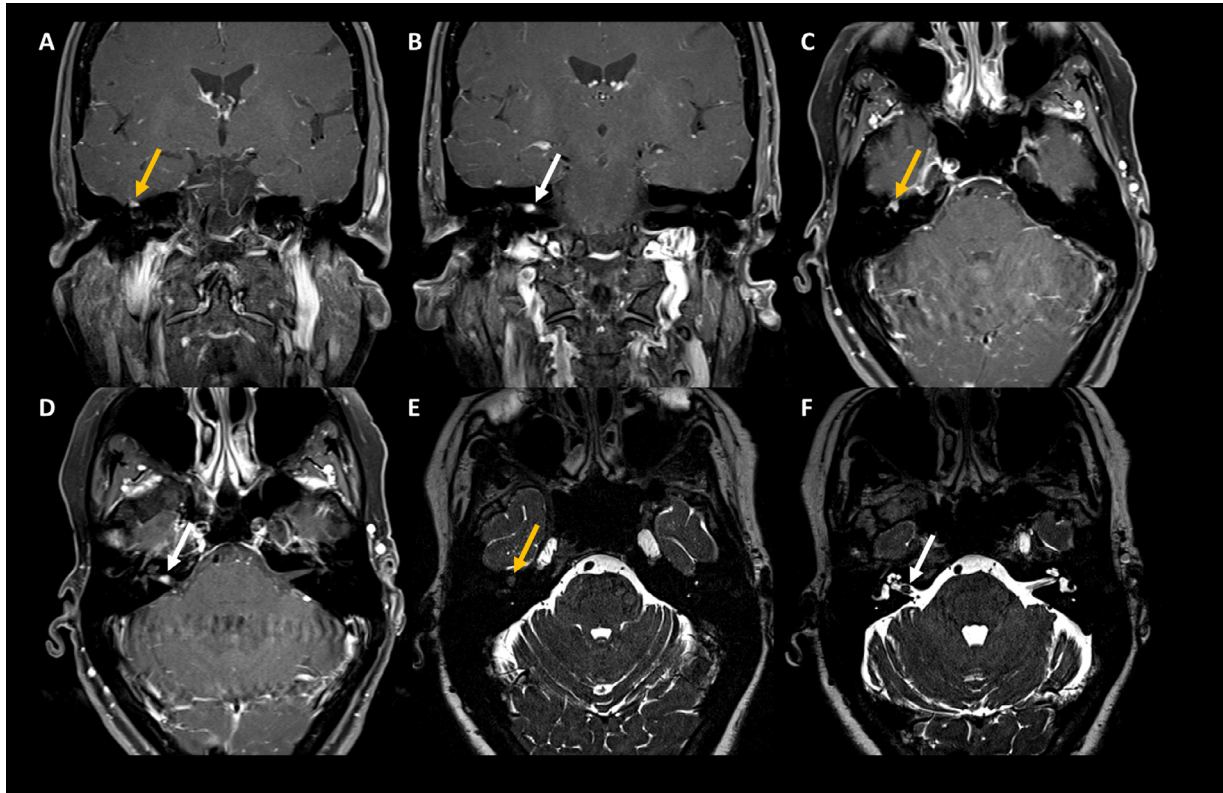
MRI internal auditory canal protocol, coronal T1 postcontrast fat-saturated images (A and B), axial T1 postcontrast fat-saturated images (C and D) and axial T2-weighted non-fat-saturated images (E and F) in a 57-year-old woman with recurrent episodes of dizziness over 6 months. Nodular oval-shaped T2-hypointense enhancing lesion measuring 6 x 7 mm was noted in the right internal auditory canal (white arrow). Furthermore, abnormal enhancement was present in the right geniculate ganglion (yellow arrow). These findings were highly suggestive of a facial nerve schwannoma.
